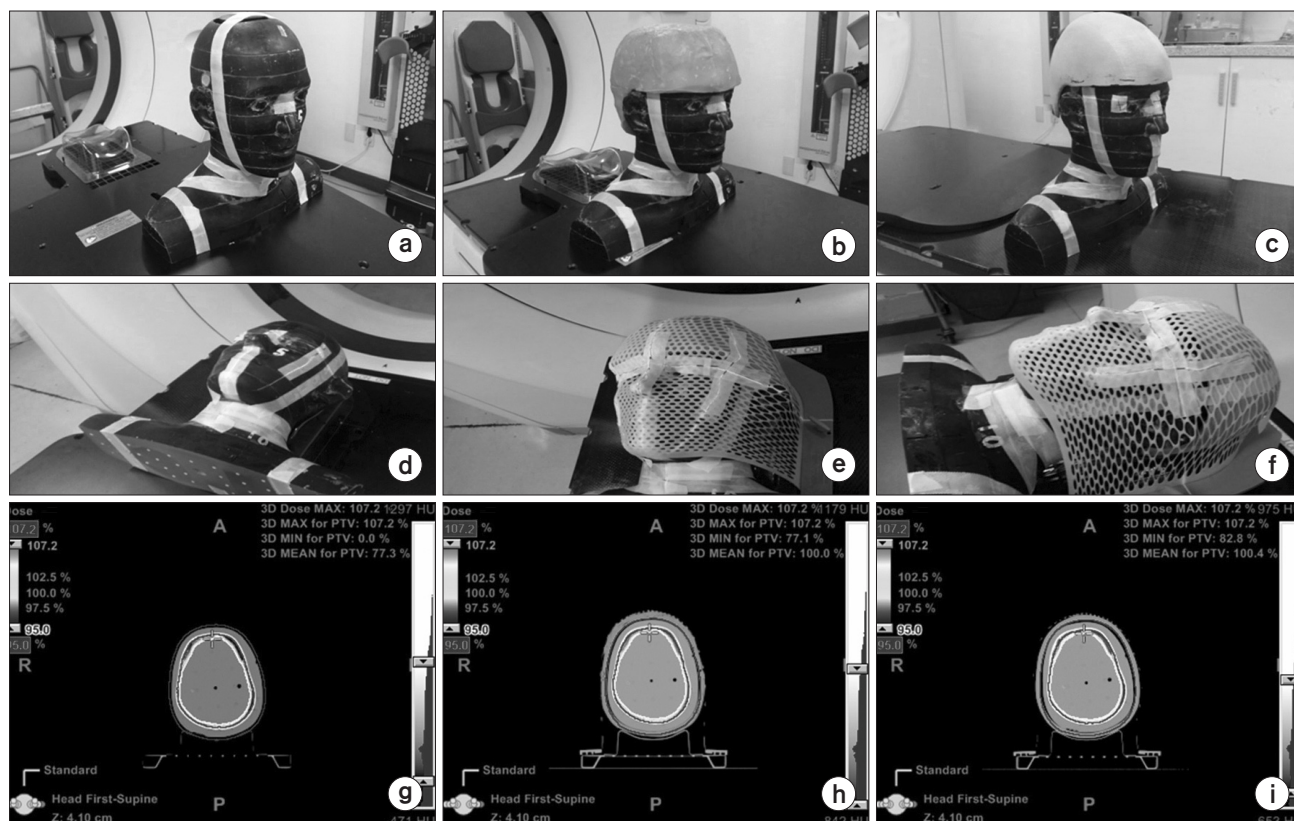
Images (a), (b), and (c) for a Non_Bolus, Wax_Bolus, and 3D Printing_Bolus; images (d), (e), and (f) taken on a CT couch before imaging; CT Images (g), (h), and (i).
